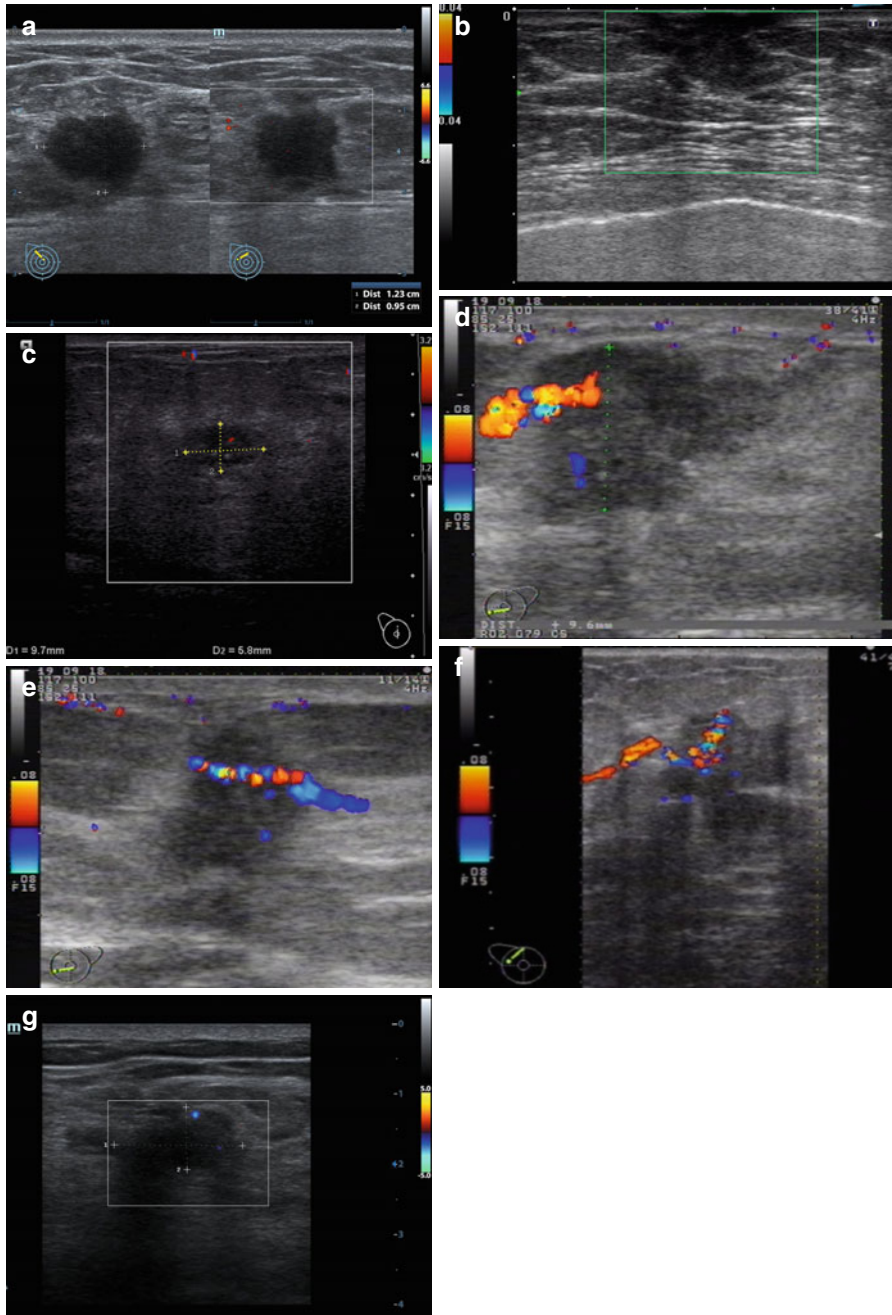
Breast carcinoma. Sonograms. (a–c) CDI. (d) Radial course of the vessel. (e–g) Penetrating vessels in a tumor
